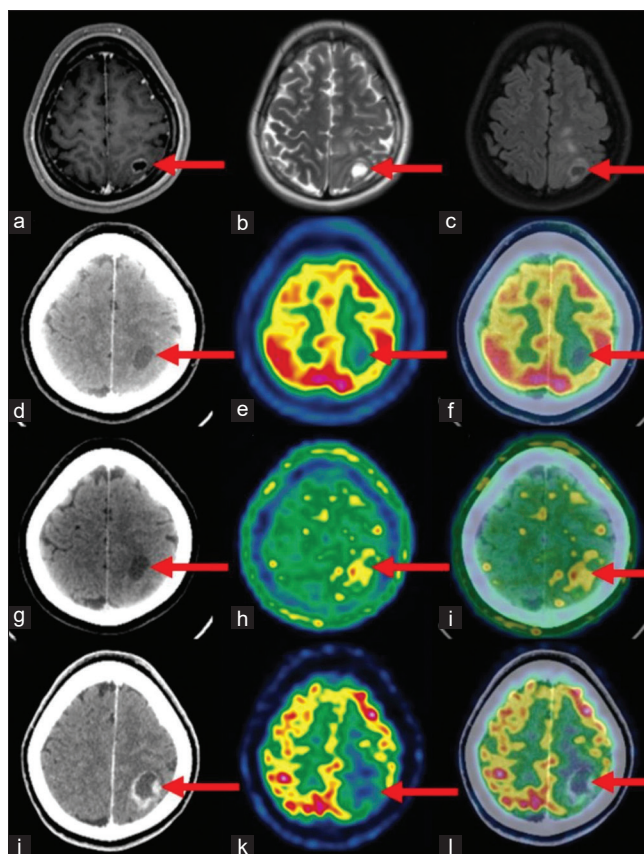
(a-c) Images showing hypointense lesion (red arrow) with peripheral enhancement on T1-weighted images, hyperintense lesion (red arrow) on T2-weighted images, and peripheral enhancement (red arrow) on T1RM images. (d-i) Images showing peripherally enhancing cystic lesion (red arrow) in left high parietal lobe with absent ^{18}F -2-fluoro-2-deoxy-D-glucose uptake and mild peripheral [^{18}F]-DOPA uptake. (j-l) ^{18}F -2-fluoro-2-deoxy-D-glucose positron emission tomography/CT repeated in another institute, images show peripherally enhancing cystic lesion (red arrow) in left high parietal lobe with absent ^{18}F -2-fluoro-2-deoxy-D-glucose uptake
